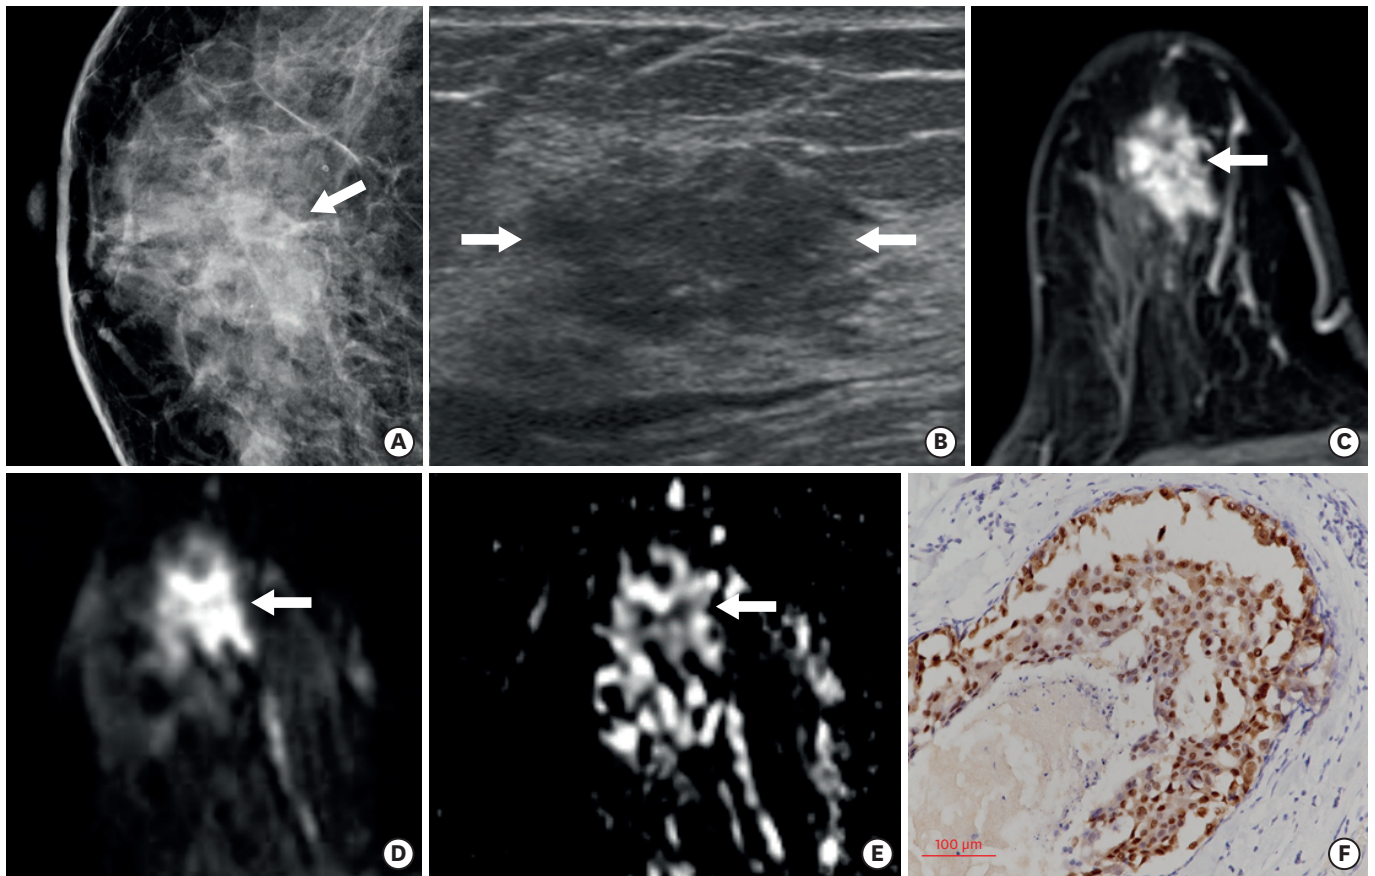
Carcinoma with apocrine differentiation in the left breast. (A) A craniocaudal view of the mammogram shows a 1.8-cm oval high-density mass (arrow) in the left inner breast. (B) An ultrasound image shows an oval microlobulated hypoechoic mass (arrow). (C) Sagittal contrast-enhanced magnetic resonance image shows an oval heterogeneously enhancing mass (arrow) in the left inner breast. (D and E) The diffusion-weighted image and ADC map show diffusion restriction in the mass (arrow in D and E), and the ADC value was  $0.953 \times 10^{-3} \text{ mm}^2/\text{sec}$ . (F) The tumor cells were immunoreactive to the androgen receptor ( $\times 200$ ). ADC = apparent diffusion coefficient.
